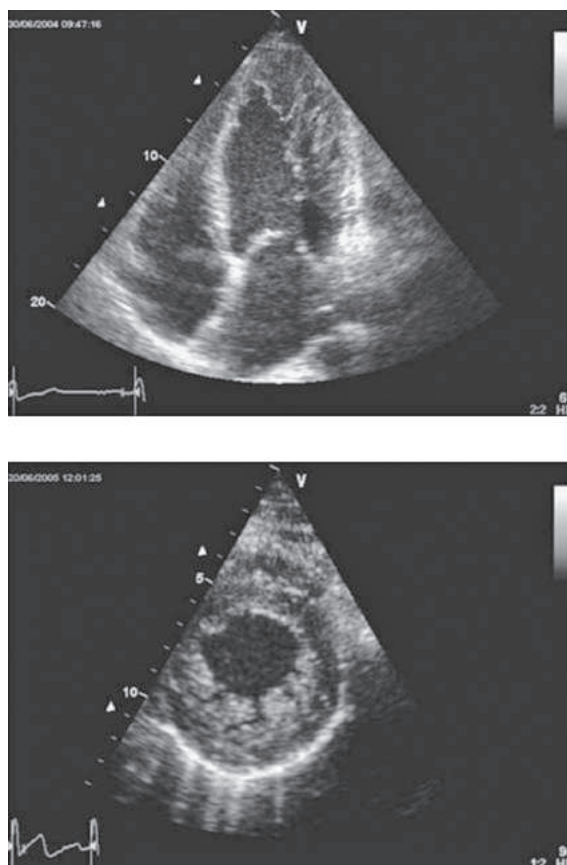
Apical echocardiographic view of a non-compacted left ventricle with extended and prominent trabeculations in the apical region and in the lateral wall. Two-layered appearance of the myocardium in a short-axis view of the left ventricle.
